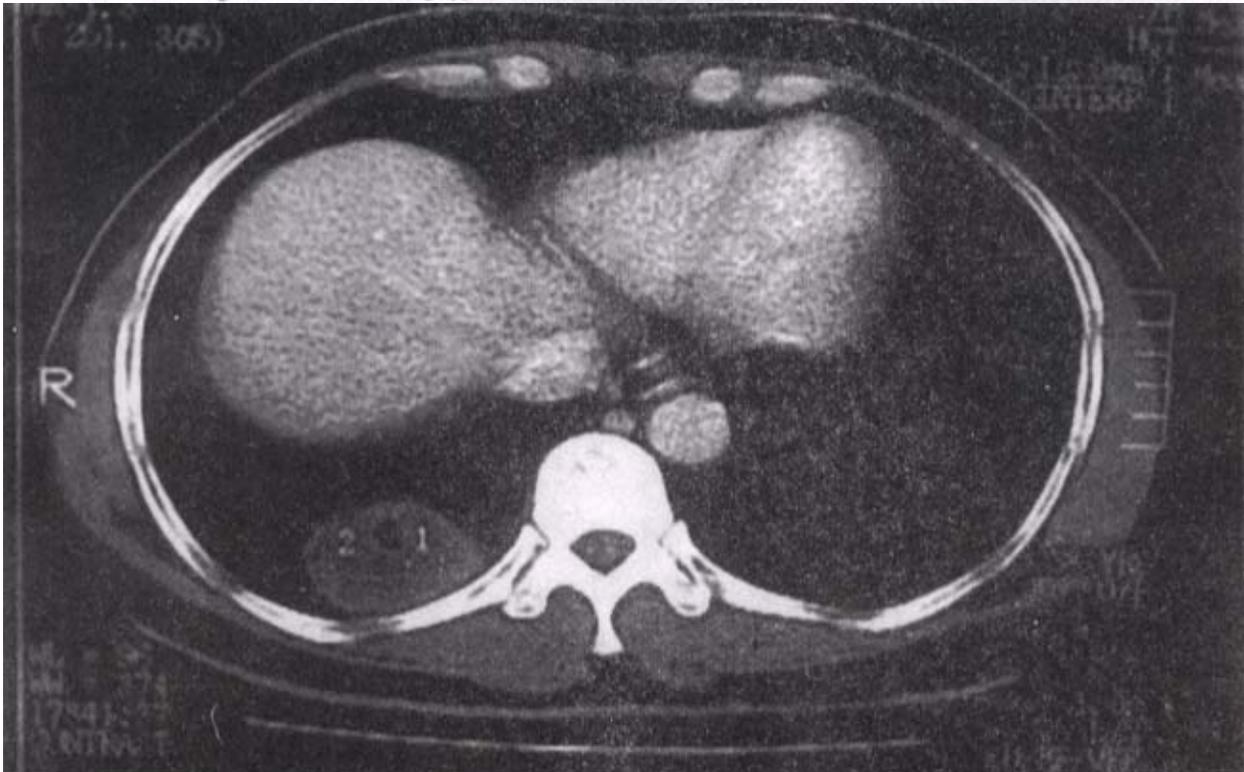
CT scan showing opacity in the basal segment of right lung.
